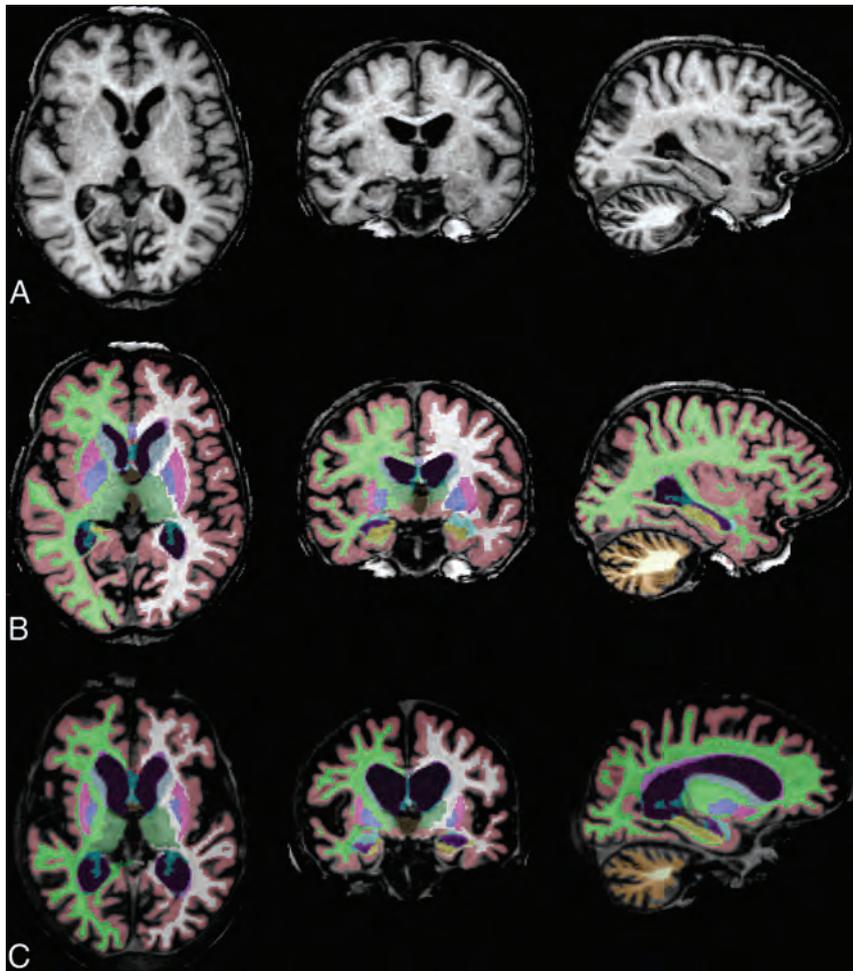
Progressive brain atrophy in CLN2 disease. Baseline 3D-T1-weighted MPRAGE images in axial, coronal, and sagittal planes (left to right) of patient 457-1 (A), segmented brain volumes (B), and segmented brain volumes 4 years later (C).
